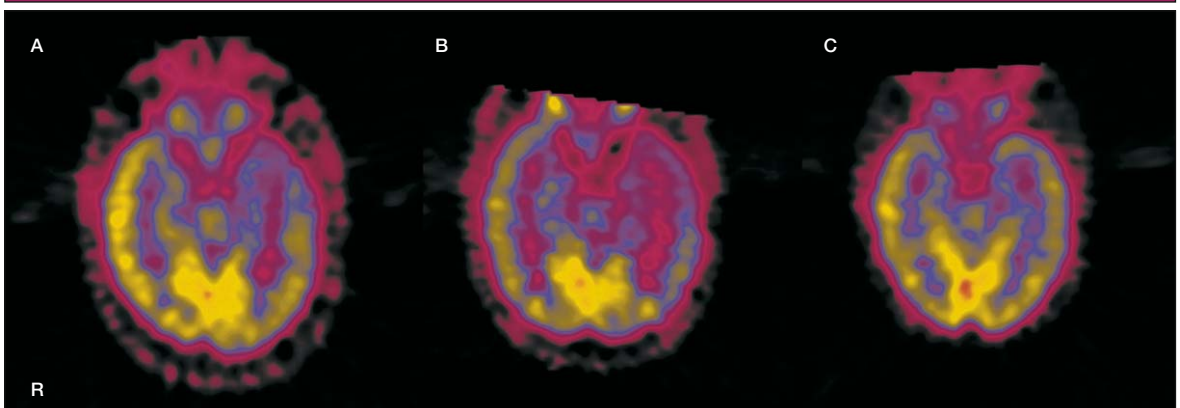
(A) Unilateral glucose hypometabolism in a 22-year-old male. FDG uptake is reduced in mesial temporal lobe structures and the tip and anterior portion of the temporal neocortex in the left hemisphere. (B) Bilateral asymmetrical glucose hypometabolism in a 19-year-old male. Reduction of FDG uptake is observed in both temporal areas, being more remarkable in the left hemisphere. (C) Equivocal symmetrical glucose metabolism in a 34-year-old female. There was no laterality in FDG uptake. Semi-quantitative analysis with regions-of-interest methods showed that the asymmetry indices of the mesial and lateral temporal areas were within normal range.
